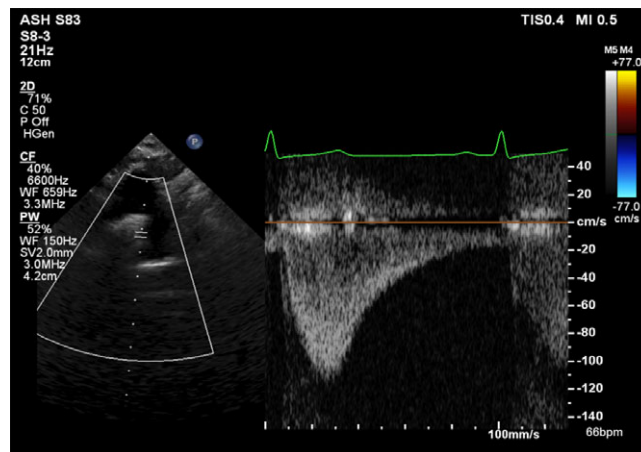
Pathologic Doppler profile in the distal aortic arch showing a “diastolic tail” – flow continuation through diastole. Peak velocity (1.1 m/s) is within the normal range.
